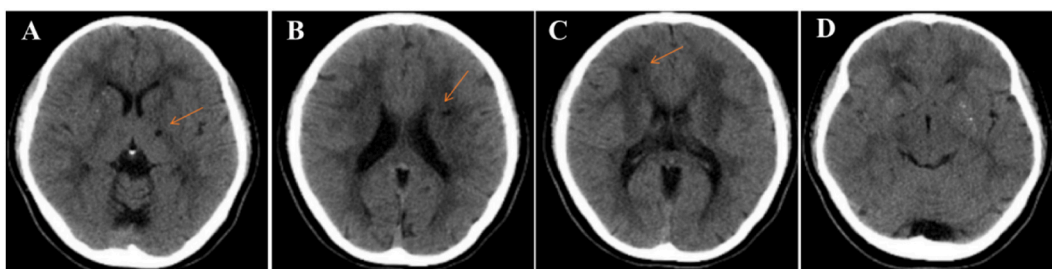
The brain CT of our patient at 12 years old showed multiple patchy low density areas (arrows) in left basal ganglia (A), corona radiata (B), and near the precornu of the right lateral ventricle (C), and punctate calcification can be seen in bilateral basal ganglia (D).
